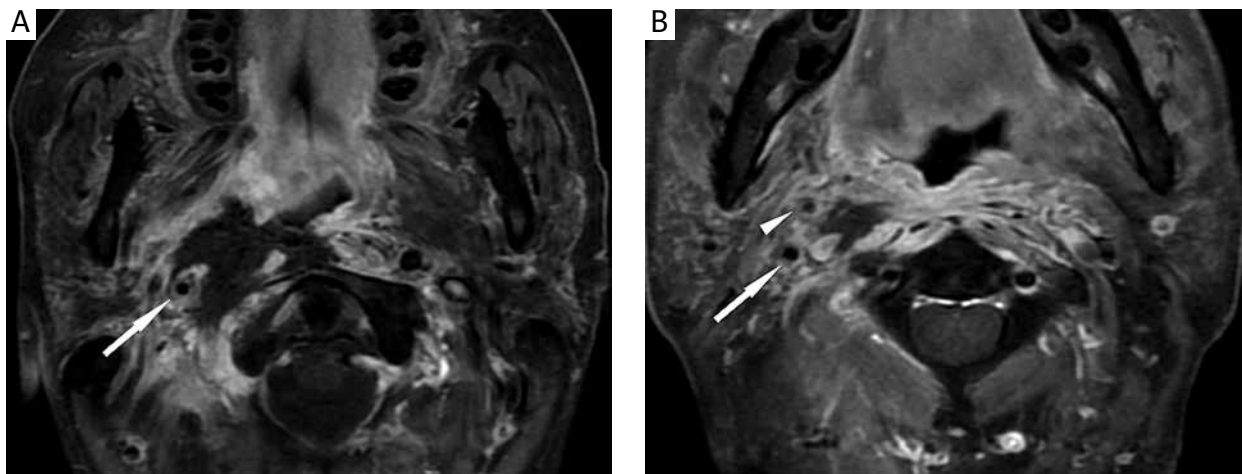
A) MRI-T1WI before anti-inflammatory treatment: right parapharynx liquefied necrotic area surrounding the right internal carotid artery sheath. B) Lingual artery level: liquefied necrotic tissue can still be seen in the parapharyngeal space
